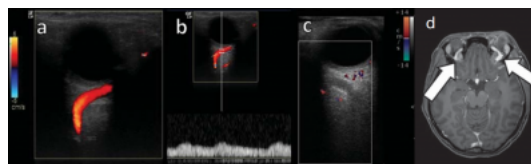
Image diagnosis confirmation: a) Blood flow in superior ophthalmic vein at color doppler study b) arterialized at spectral Doppler superior ophthalmic vein with low resistance flow, c) Superior ophthalmic vein, d) Magnetic resonance correlation in contrast-enhanced T1-weighted sequence. Modified from Santos et al.
